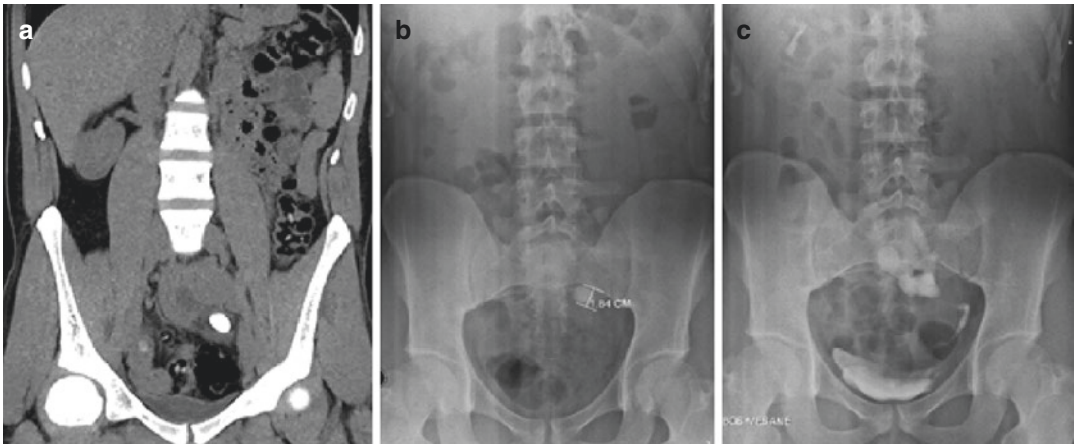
Computed tomography with (a) intravenous urography (b, c) of a patient with a 1.84 cm calculi within a left pelvic ectopic kidney [74]
